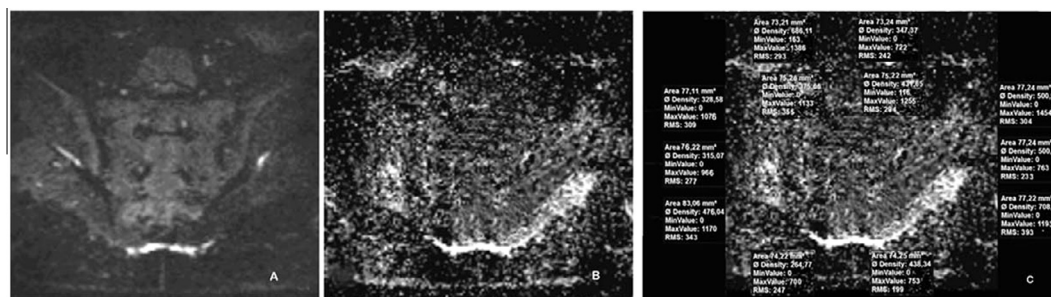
28 year-old man with chronic LBP of mechanical origin. T₂WI, DWI shows normal both surfaces of both SIJ_s (A, B). ADC map shows 12 ROI placed in sub articular surface of SIJ_s (C).
